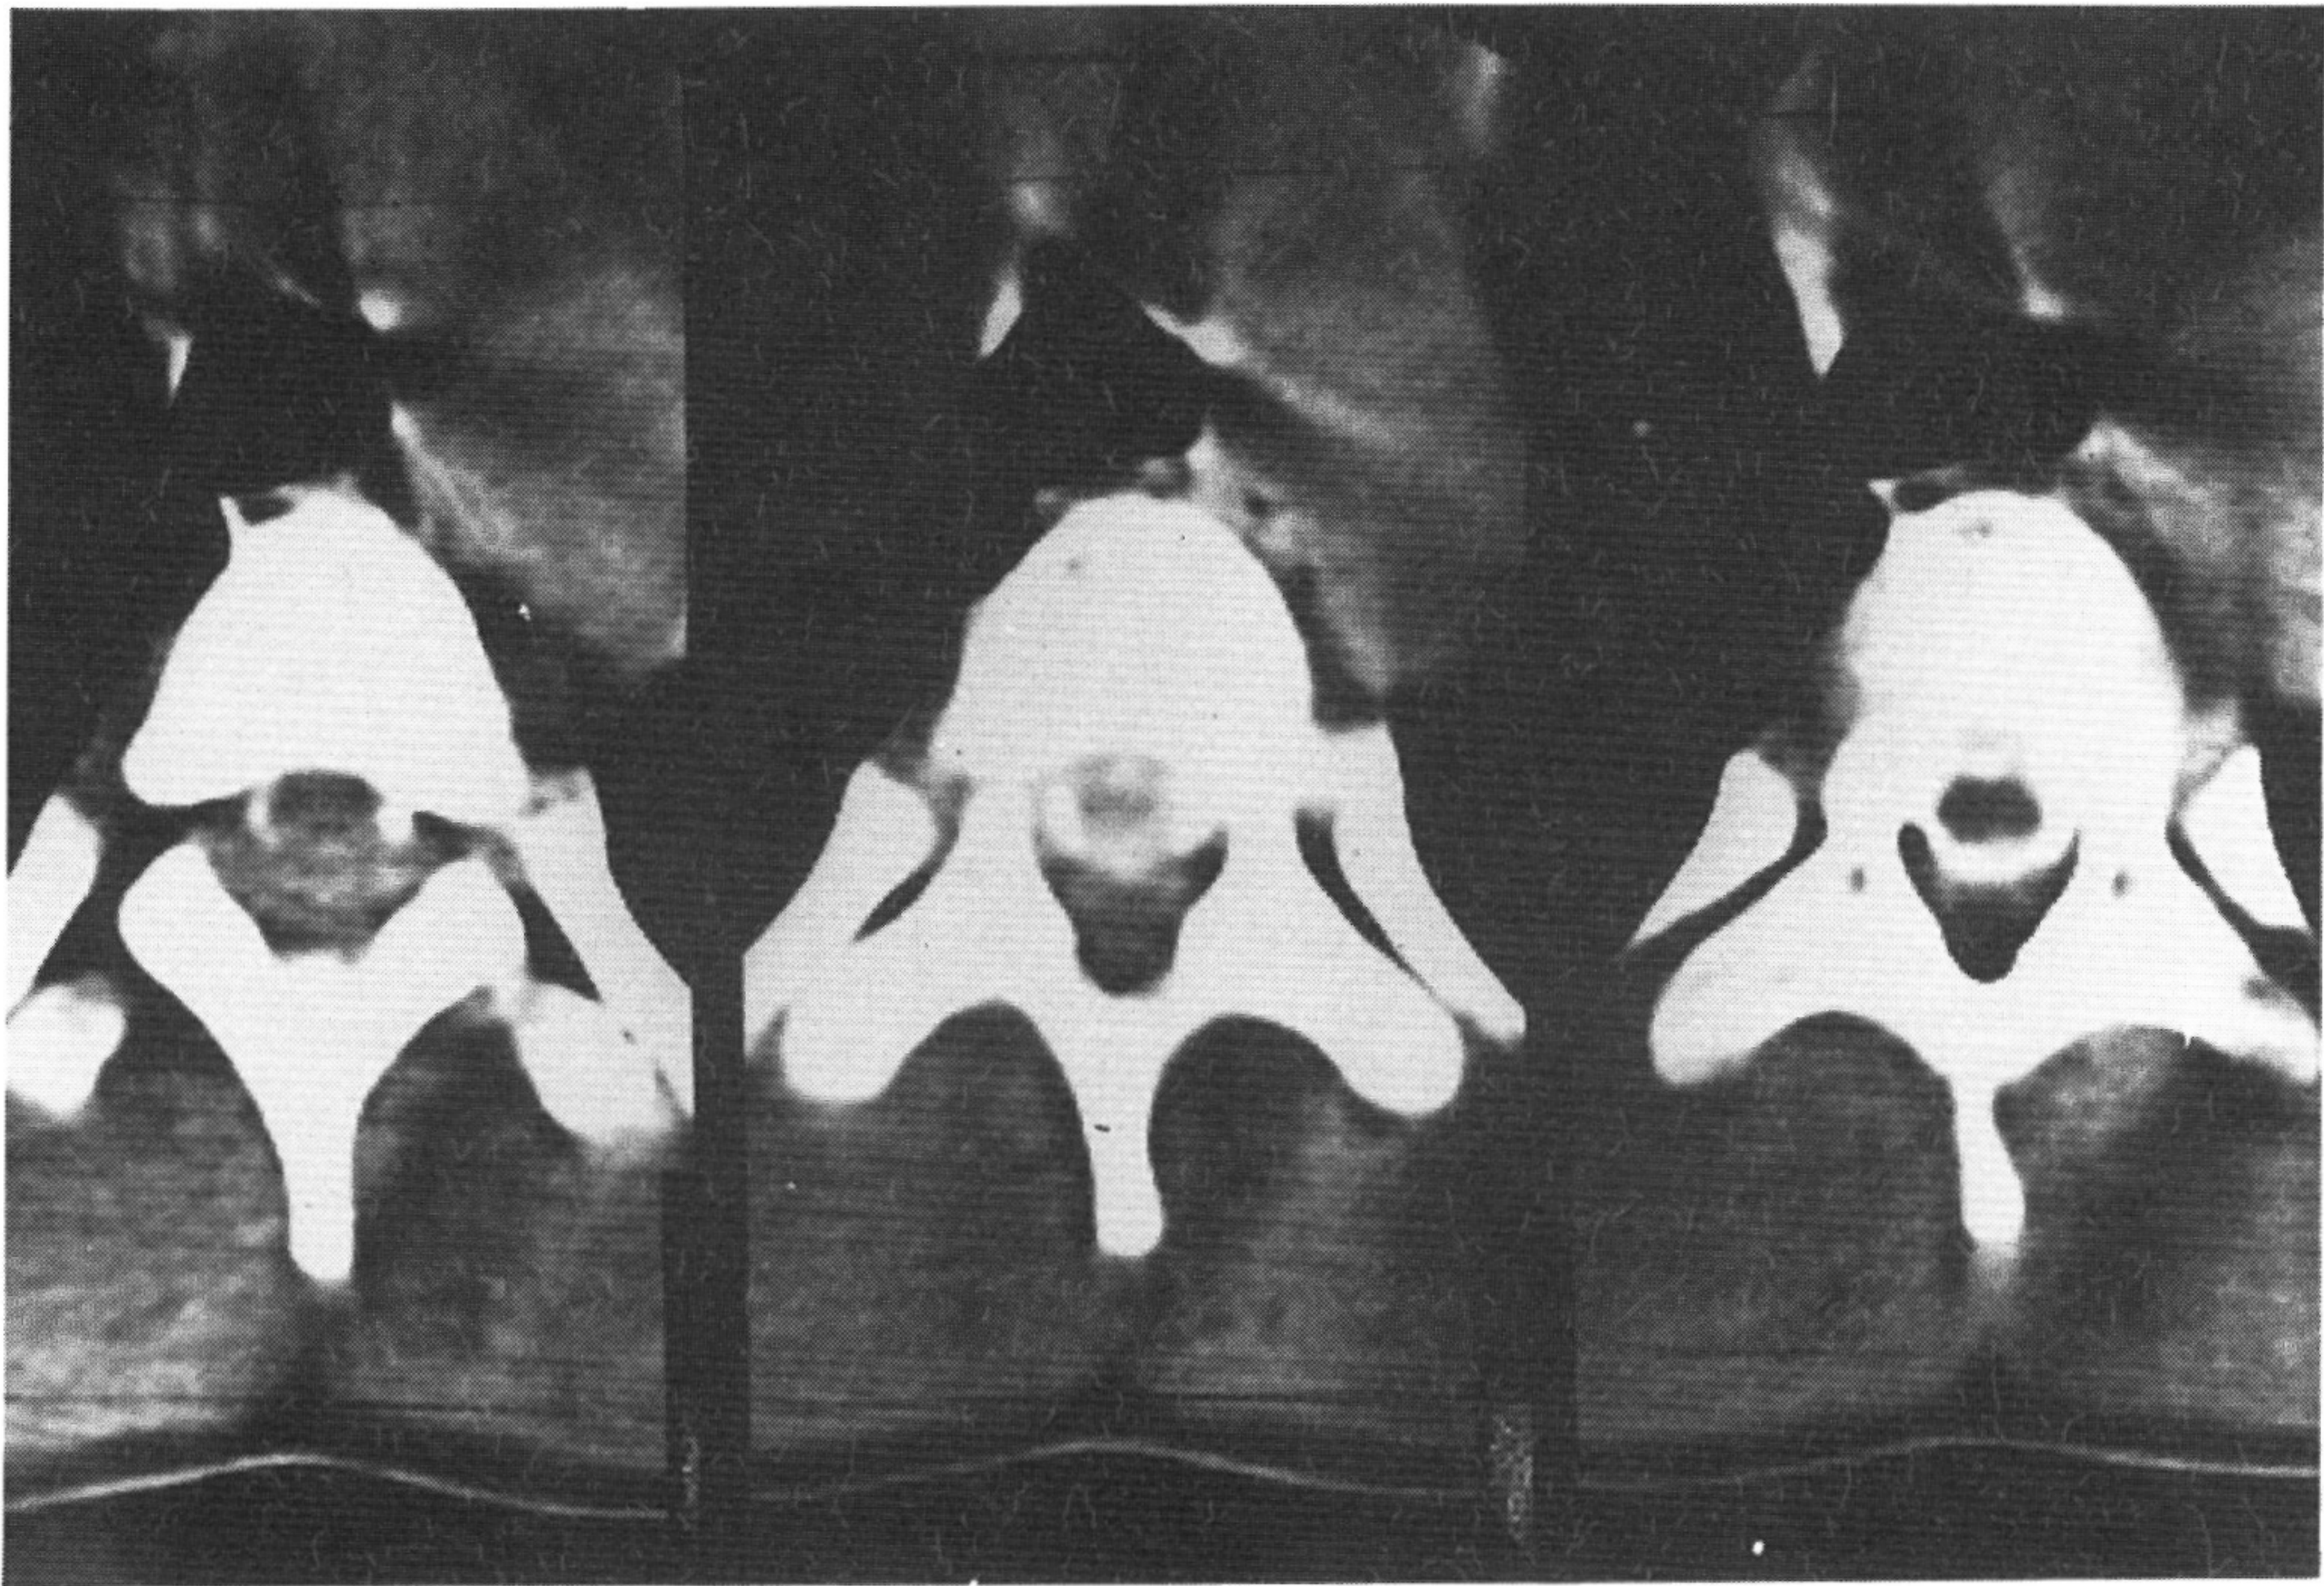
Myelographic CT showing anterior displacement of the spinal cord and obstruction of the contrast medium-filled subarachnoid space by a posterior epidural soft tissue mass.
